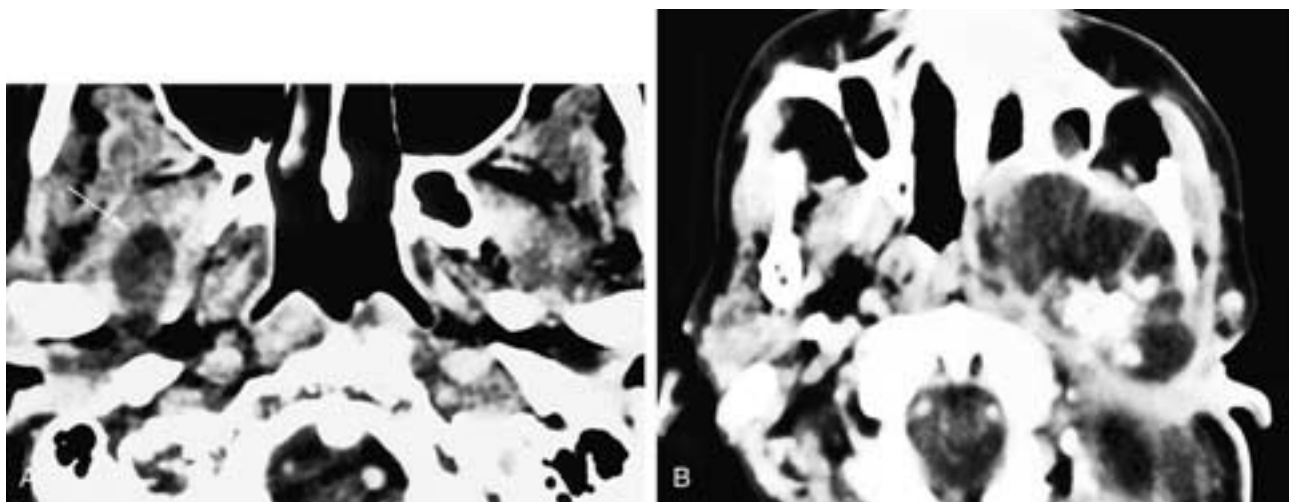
Axial contrast-enhanced CT scan (A) shows a fairly low-attenuation, sausage-shaped mass (arrow) extending from the skull base down into the parapharyngeal and masticator spaces. This was a chondroma. Axial contrast-enhanced CT scan (B) shows an overall low-attenuation mass in the left masticator and parapharyngeal spaces, with destruction of the posterior left maxilla. Within the mass are large tumoral calcifications. Note the difference in the appearance of the calcifications in this chondrosarcoma from those in aneurysms (see Figs. 38-14B and 38-27).
